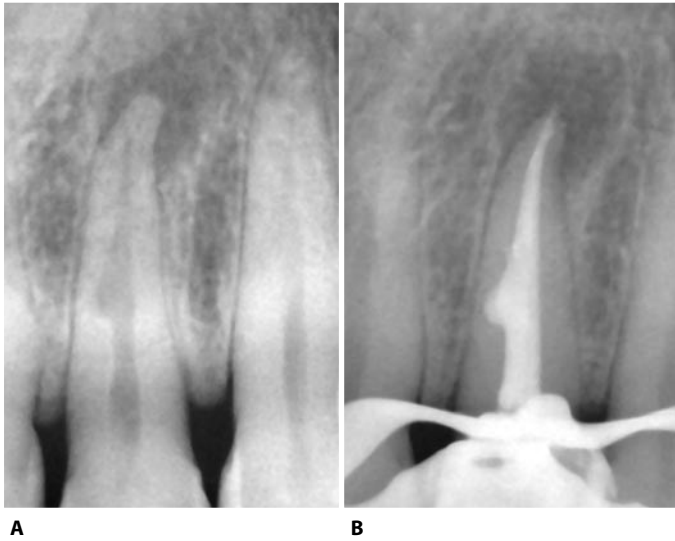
Multiphase obturation technique. Canal obturation of an upper lateral incisor. A. The pre-operative radiograph shows the presence of internal root resorption. B. Post operative radiograph; canal obturation carried out with multiphase technique, which has allowed one to obtain an effective filling of the endodontic system with a single introduction of thermoplastic gutta-percha in a few seconds.
